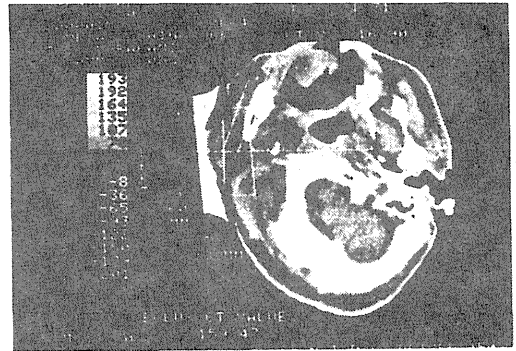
CT view of neck metastasis with alginate bolus.
